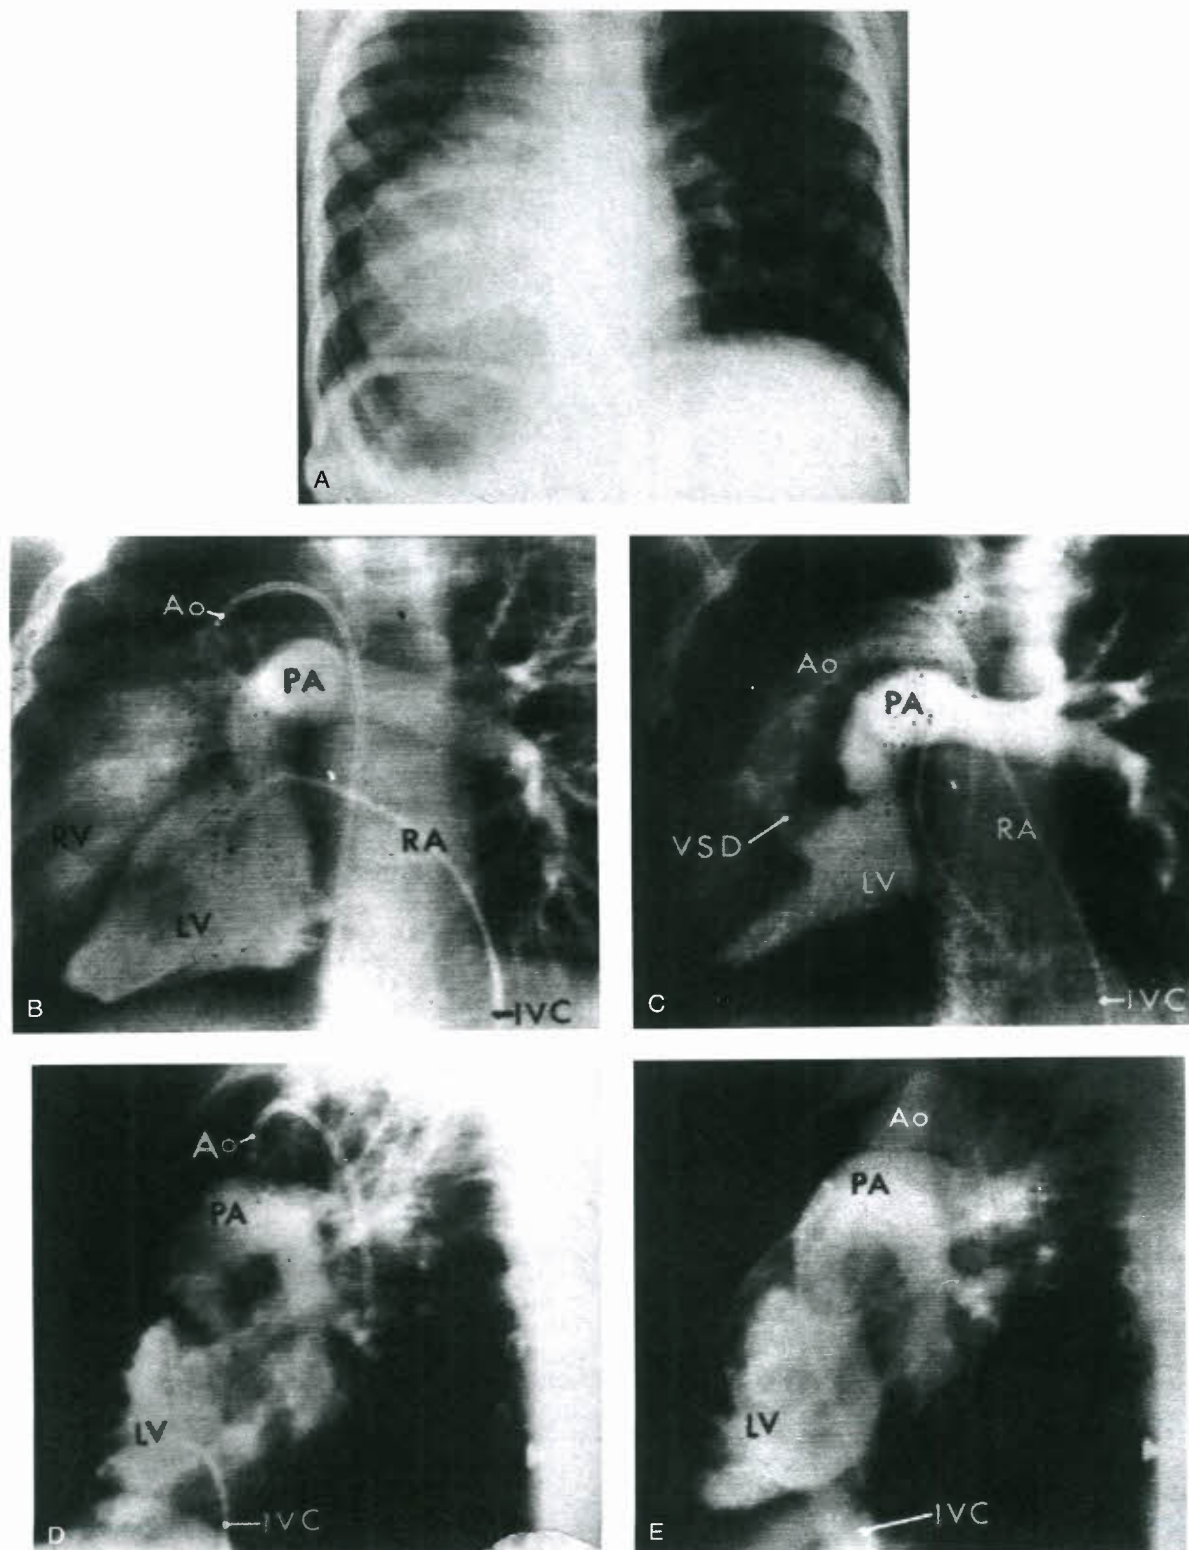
Dextrocardia with situs inversus and atrioventricular and ventriculoarterial discordance (congenitally corrected transposition). A: The posteroanterior chest radiograph demonstrates dextrocardia with a right-sided stomach bubble consistent with situs inversus and dextrocardia. The angiocardiograms (B–E) demonstrate a catheter in a left-sided inferior vena cava (IVC) joining a left-sided systemic venous atrium (RA), which connects with a morphologic left ventricle (LV) and a left-sided pulmonary artery (PA). Note that the ascending aorta (Ao) is right posterior in relation to the pulmonary valve because of marked cardiac rotation to the right. (VSD, ventricular septal defect.) (From Van Praagh R, Van Praagh S, Vlad P, et al. Diagnosis of anatomic types of dextrocardia. *Am J Cardiol* 1965;15:234–243, with permission.)
